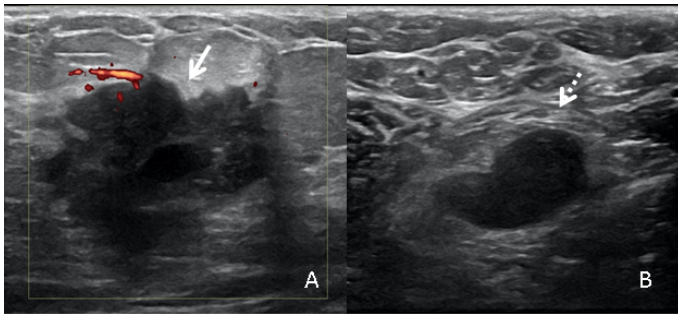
(A) Ultrasound power Doppler image shows an irregular hypoechoic solid palpable mass with angulated margins, central cystic component, peripheral vascularity and posterior acoustic shadowing in the left breast 2:00 axis 4 cm from the nipple (solid arrow). (B) Grey scale ultrasound image demonstrates a morphologically abnormal left axillary lymph node with diffuse cortical thickening and absence of the fatty hilum (dotted arrow).
